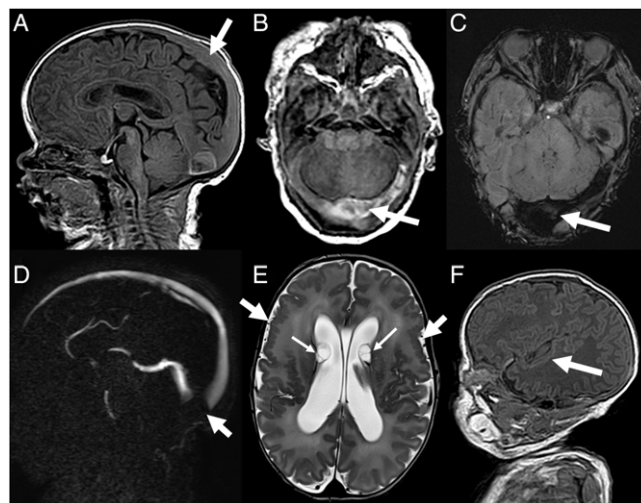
Brain MRI. Sagittal 3D T1 GRE (A) and axial reformations (B) showing enlarged superior sagittal sinus (arrow), with abnormal heterogeneous increased signal intensity in the torcula and left transverse venous sinus, with associated increased magnetic susceptibility on SWI (C). On phase contrast MRV (D), there is a corresponding large "filling defect" (absence of flow related enhancement), consistent with thrombosis (arrow). Axial T2 (E) and sagittal T1 (F) images demonstrate bilateral symmetrical enlargement of the lateral ventricles and extensive bilateral frontal, insular, and peri-insular polymicrogyria (thick arrows). Nonspecific subependymal cysts were also seen bilaterally (thin arrows).
